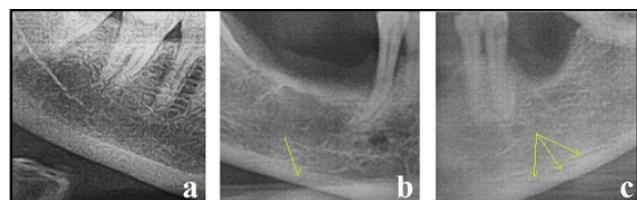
Panoramic radiographs of patients with MCI scores 1 (a), 2 (b) and 3 (c) respectively. Defects in basis mandible are demonstrated by green arrows.
